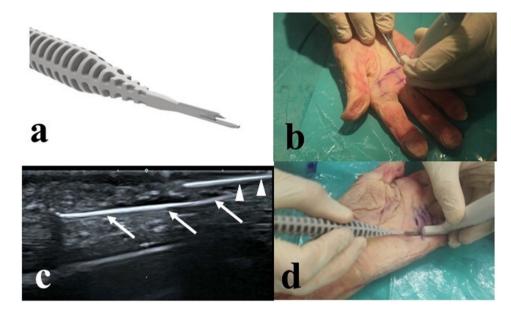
Knife technique. (a) Close up of the tip of the knife showing the long and short prongs. (b) Enlarging the space via mosquito artery forceps. (c and d) The knife was introduced under ultrasound guidance to perform the release. The arrowheads indicate the shorter upper jaw of the knife. The arrow indicates the longer lower jaw of the knife
